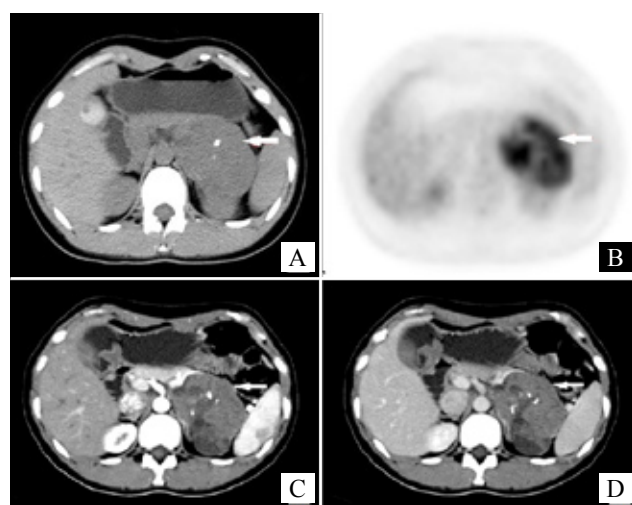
A pathology proven benign SPT located in the pancreatic tail (arrow) of a 26 years old woman showed avid ^{18}F -FDG uptake in the peripheral zone (B, solid white arrow, SUVmax of 7.5), corresponding to the solid part of the tumor enhanced after contrast administration (C-D). The spleen vessel was suppressed but not invaded.
